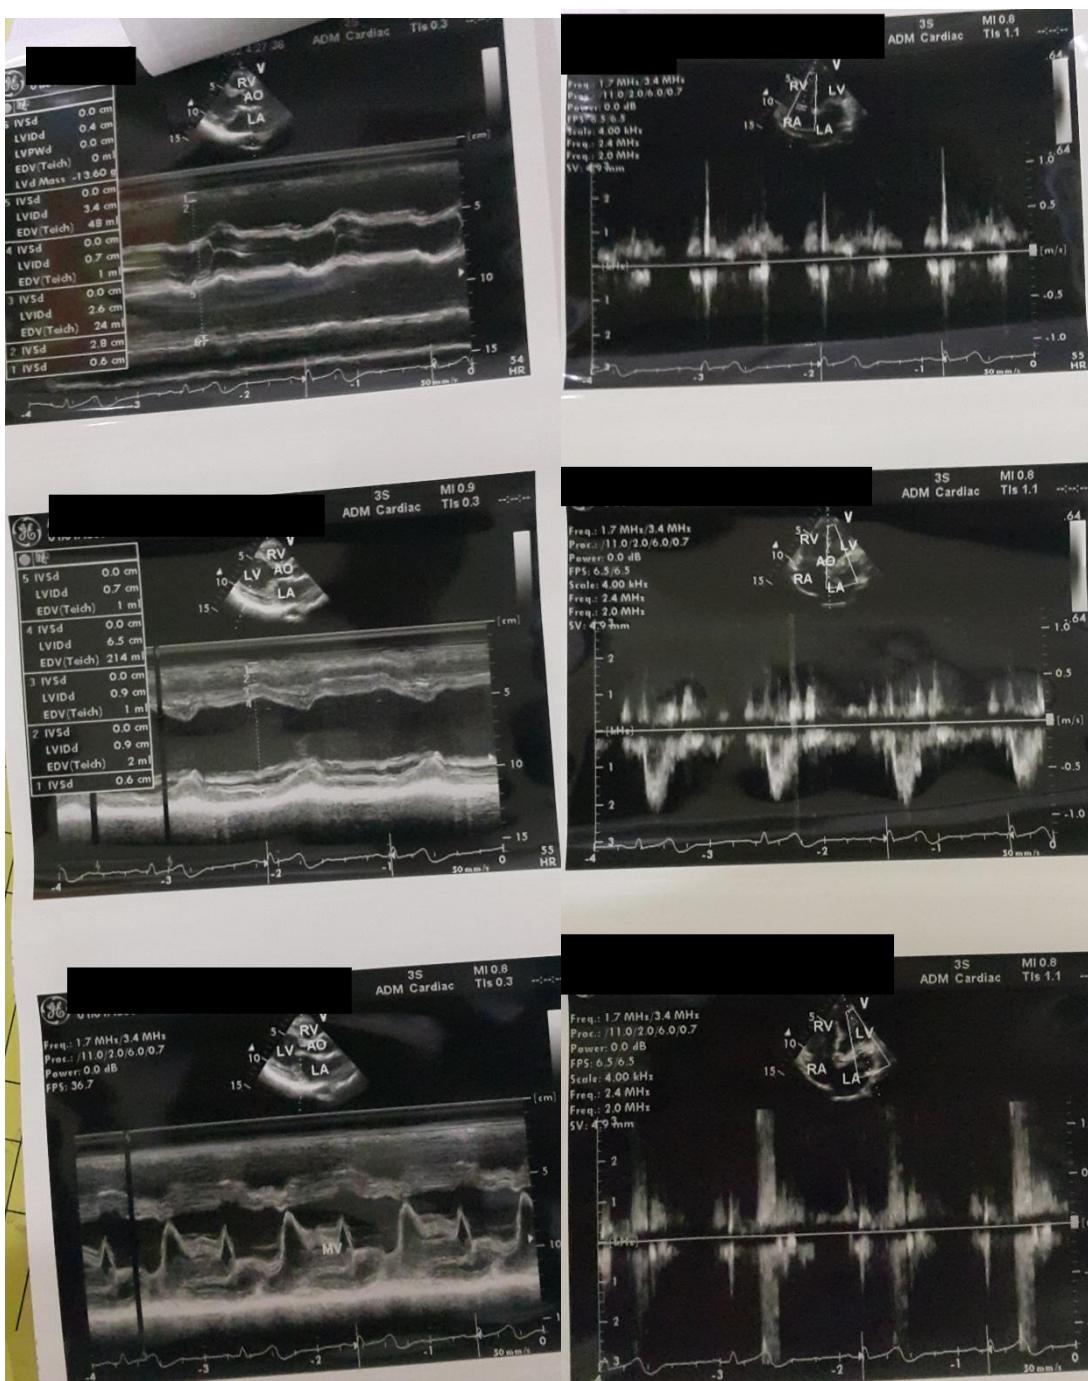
Patient's Echocardiography
